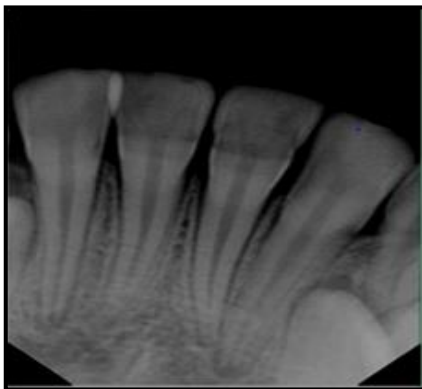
Radiograph showing crown dilaceration in middle third
